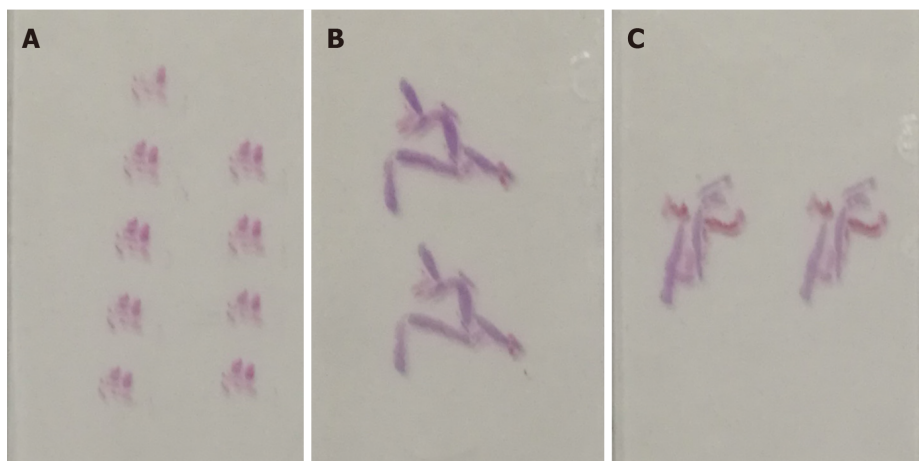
Slide samples. A: The shattered slide samples from transabdominal ultrasound-guided biopsy; B and C: The slide samples from transperineal biopsy guided by endorectal ultrasound, which were abundant and intact.
